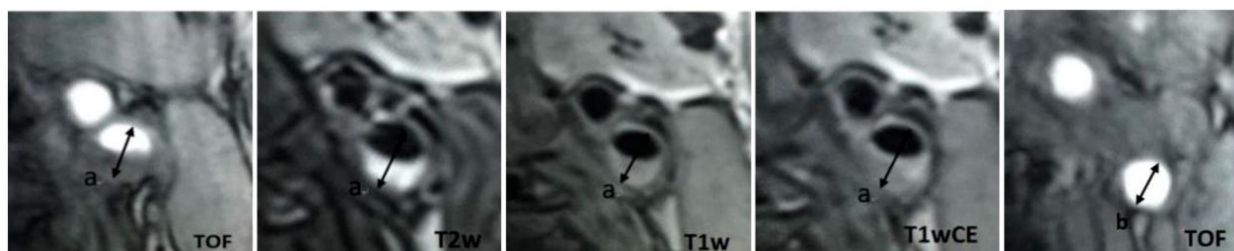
Measurement of the ERR by high-resolution MRI of the carotid artery at 3Tesla. ERR = maximum distance between the lumen and the outer border of the plaque in the ICA (a) divided by the lumen diameter within 1 centimeter of the plaque at the distal ipsilateral ICA measured on 3d TOF image (b).
